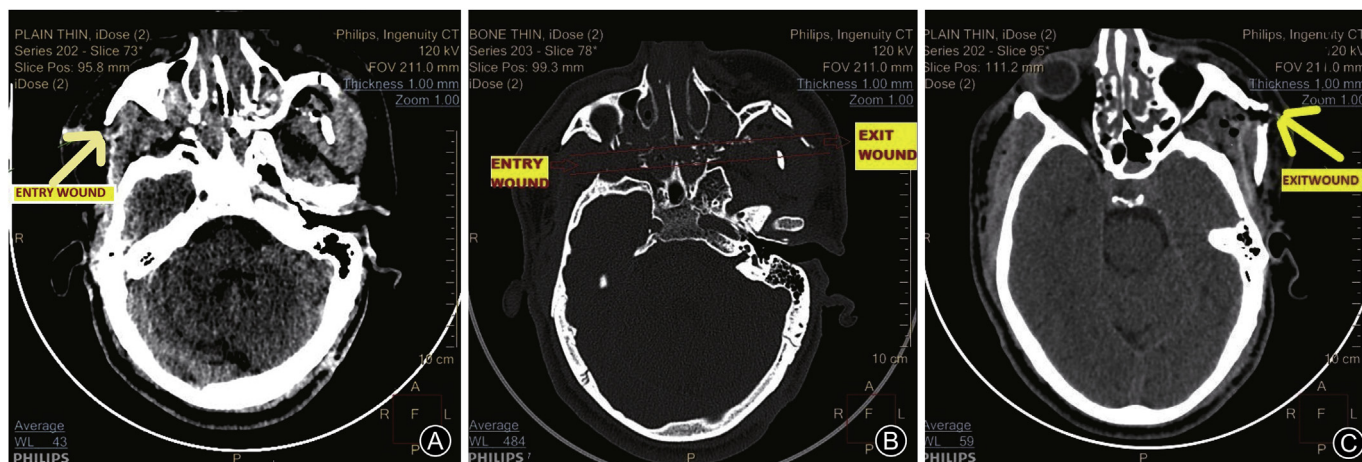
Non-contrast CT images of head showing: (A) entry wound, (B) tract of gunshot projectile, and (C) exit wound.
